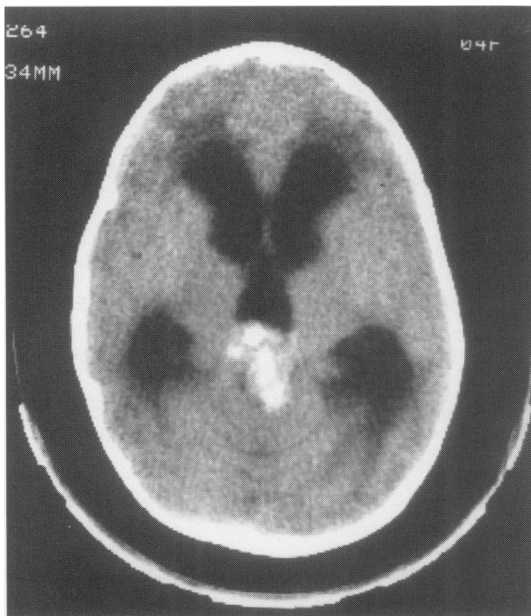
CT head scan of the patient showing a calcified mass in the pineal region with marked triventricular hydrocephalus
